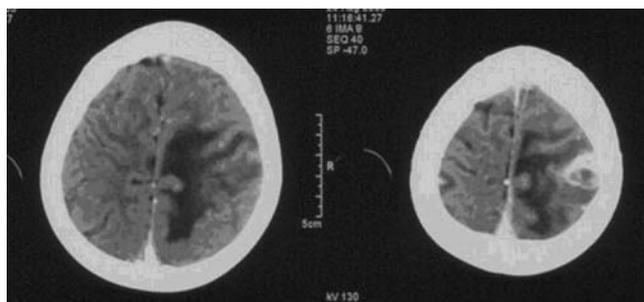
Brain computed tomography (CT) scan of the 5-year-old boy with chronic granulomatous disease (CGD), taken on hospital admission
